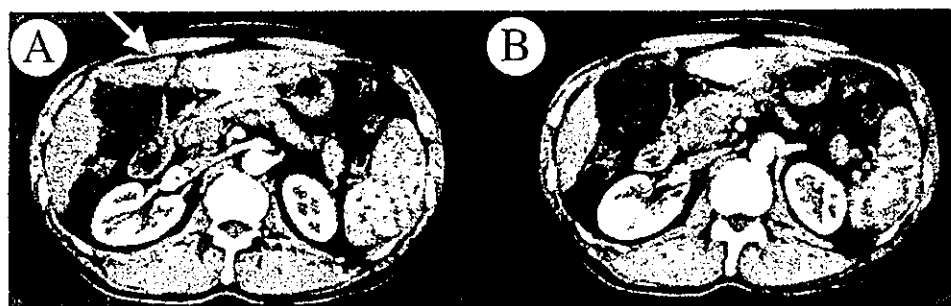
Contrast-enhanced CT (early phase) of HCC of the S3 region of the liver before the laparoscopic PEI-RFA. Lipiodol deposit was observed homogeneously in the entire region of the tumorous lesion. A tiny nodule showing the early enhancement was also detected on the surface of the S4 region of the liver (arrow).
